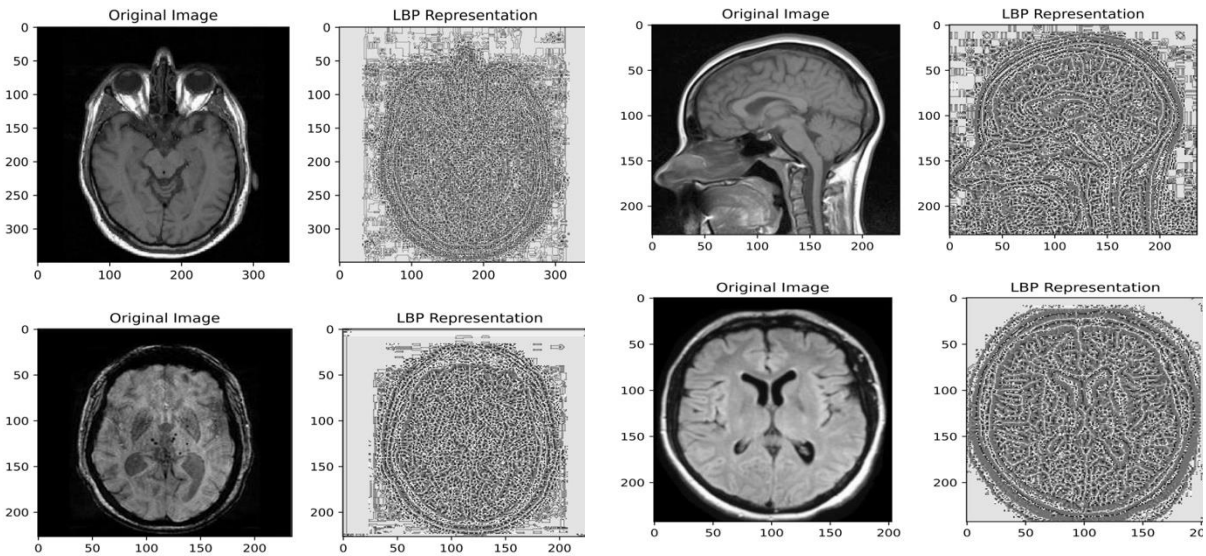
Local Binary Pattern (LBP) feature maps for non-neoplastic control samples: Side-by-side comparison of original structural brain MRI slices and their corresponding LBP feature representations, highlighting the baseline micro-texture distribution of healthy tissue.
